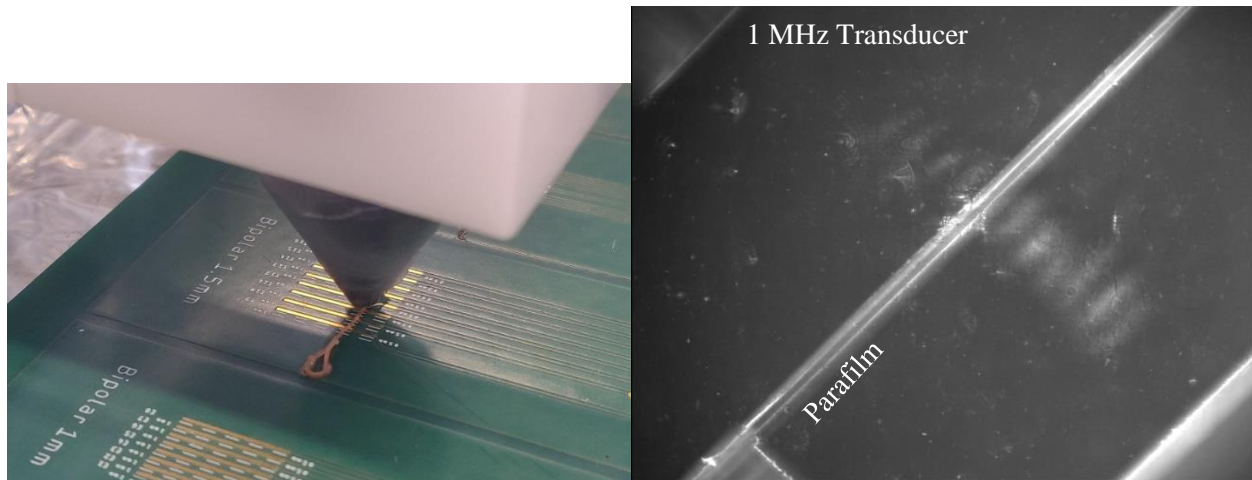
Photographs of explanted *Lumbricus Terrestris* medial nerve cords under 1 MHz ultrasonication. a) The transducer is suspended above the interface PCB and acoustically coupled to the nerve through a coupling cone. The nerve cord is coupled to gold line-electrodes. b) Nerve chord under sonication. The nerve is suspended on a thin parafilm in a saline bath. Ultrasound waves were visualized using Schlieren optics. Recording electrodes are not shown.
